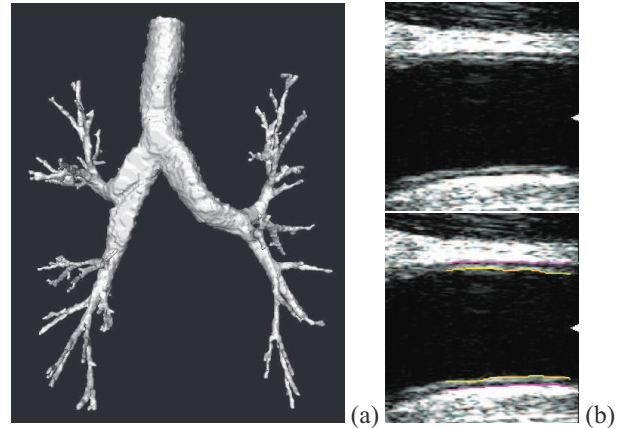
(a) Intrathoracic airway tree segmentation from multi-detector X-ray CT. (b) Ultrasound image of a human carotid artery with intima-media thickness automatically determined.
